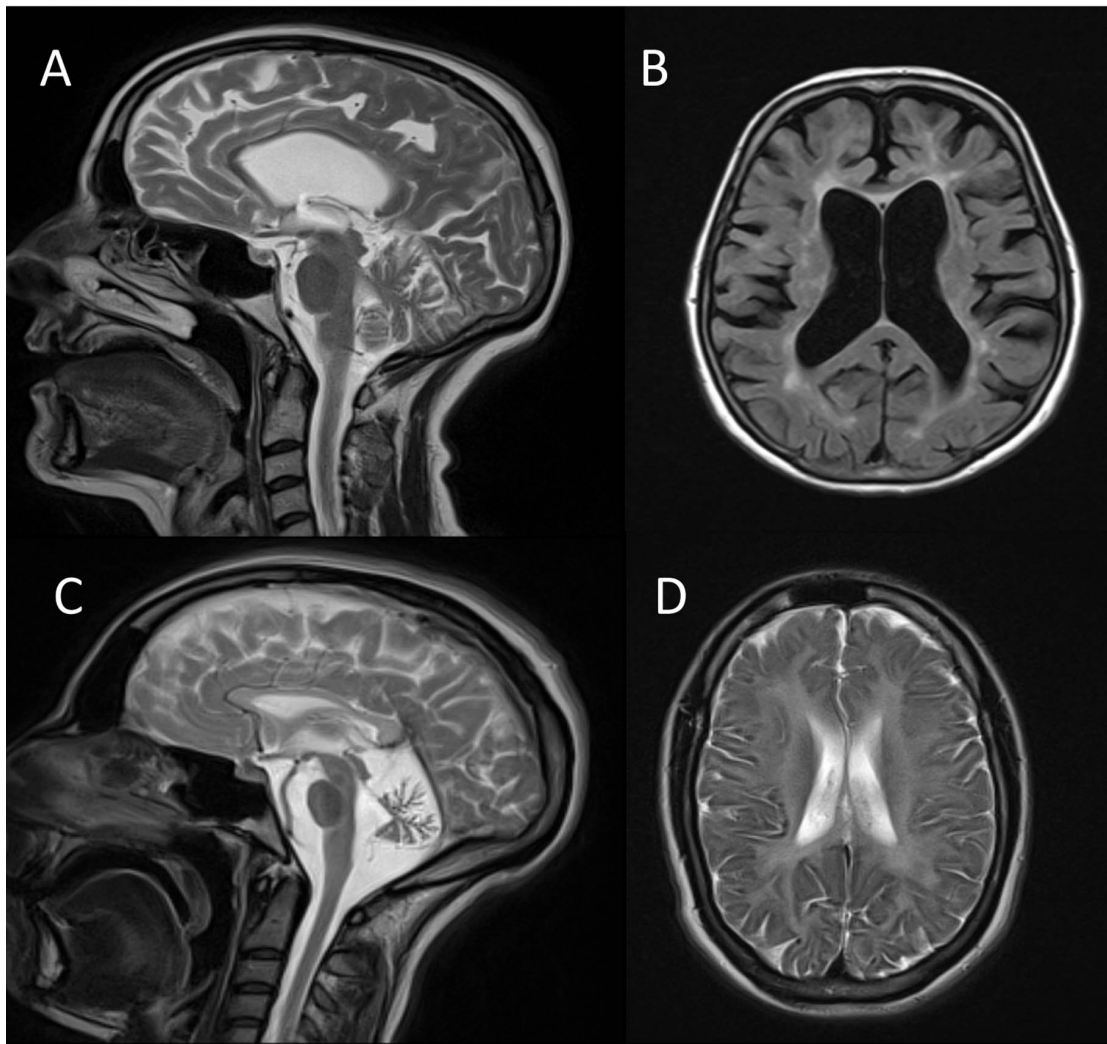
MRI from the mother P13 and daughter P12. Brain MRI for patient P13, the mother (A and B) and patient P12, the daughter (C and D) revealed leukodystrophy and cerebellar atrophy in both patients. T2 and T1 images (A and B) revealed generalized atrophy and periventricular high signal, indicative of an abnormality within the white matter. T2 images (C and D) showed marked cerebellar atrophy and diffuse hypomyelination. Adapted from Pyle *et al.*, 2014
